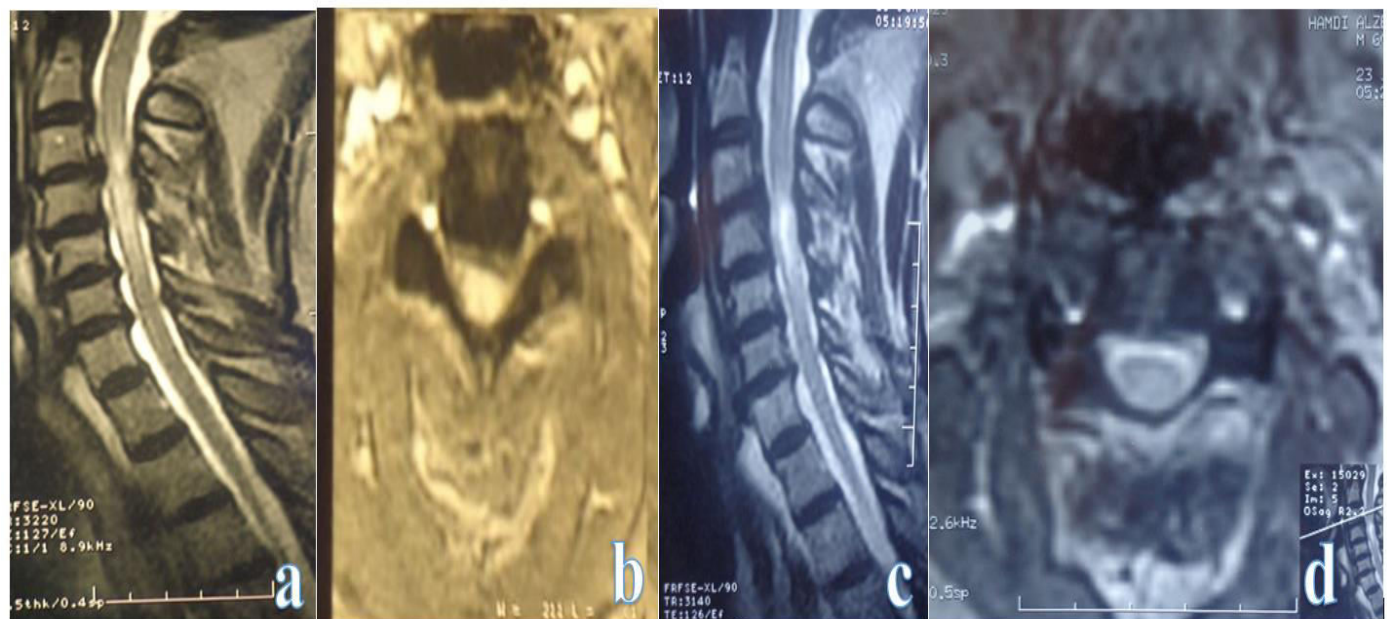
A & B Preoperative MRI cervical spine T2 WI sagittal and axial planes reveals multilevel disc lesions more evident at C3-4 with left postero lateral disc bulge compromising the spinal cord resulted in T2 intramedullary hyperintense signals impressive of compressive myelopathy as well as syrinx. C&D Post ACDF surgery T2WI sagittal and axial planes reveals spinal cord decompression with restoration of anterior subarachnoid space.
